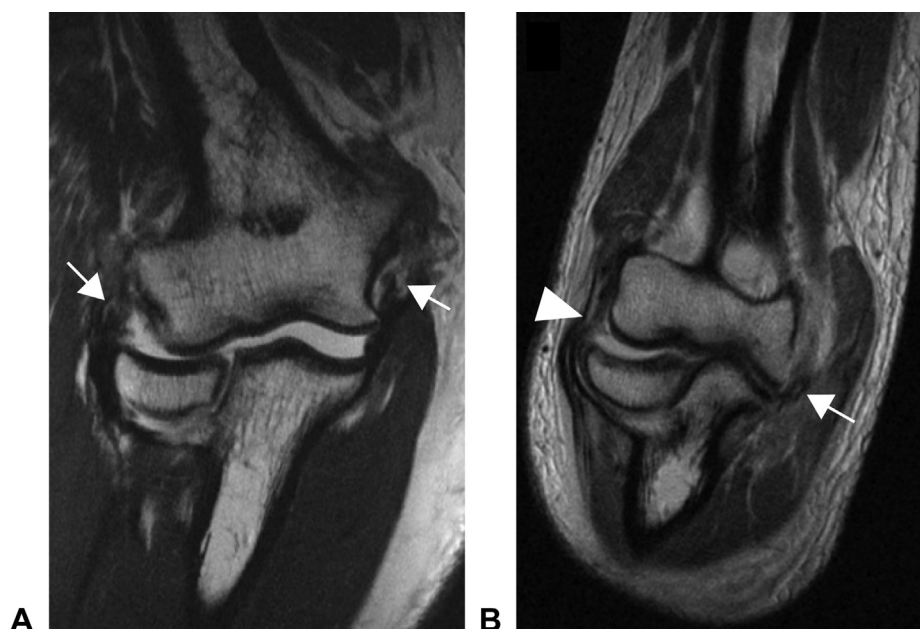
Findings on selected postdislocation MRI images. A Patient with complete AAMCL and PAMCL avulsions along with LUCL and RCL avulsions from their respective humeral origins (arrows). Image also depicts subluxation of radial head with medial opening of ulnohumeral joint. B Patient with complete AAMCL and PAMCL proximal avulsions (arrow) with concomitant proximal partial tears of the LUCL (arrowhead) and RCL.
